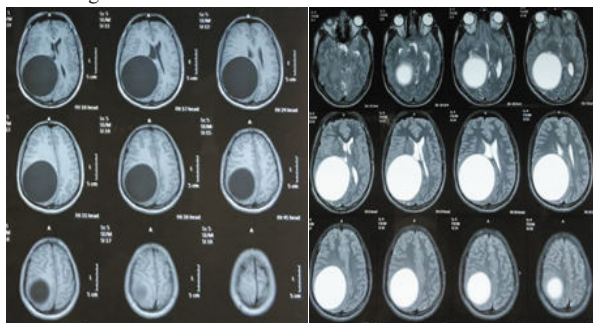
(a and b) T1, T2 images of MRI Brain showing intra axial cystic lesion in right parieto-occipital lobe.
